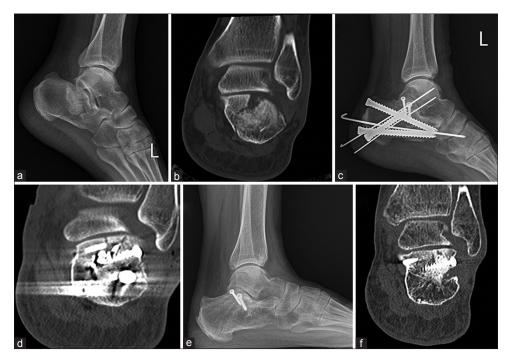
A case of a 50-year-old female patient. (a) Preoperative radiograph of ankle joint lateral view showing a calcaneal fracture with joint depression. (b) Preoperative computed tomography showing calcaneal fracture with Sander's Type 2B. (c) Immediately postoperative radiograph of ankle joint lateral view showing a well-reduced calcaneal fracture using 7.0-mm cannulated screws. (d) Immediately postoperative computed tomography showing an anatomical reduction of a posterior facet. (e) Postoperative radiograph of ankle joint lateral view taken at 1 year after surgery showing complete bony union. (f) Postoperative computed tomography taken at 1 year after surgery showing complete bony union
